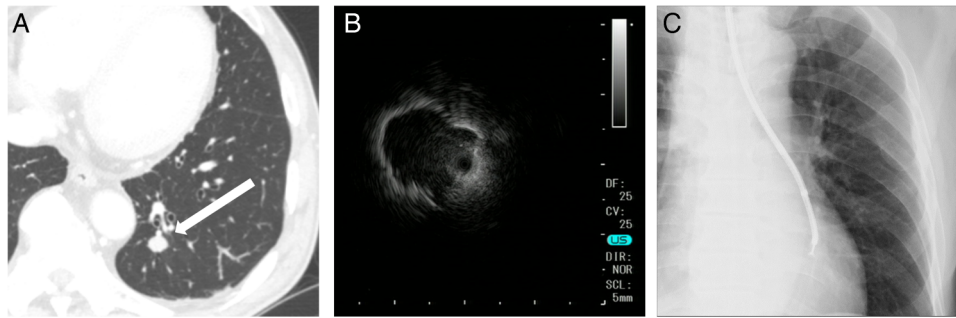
Successful tissue collection in patients with relapse of EGFR-positive adenocarcinoma after EGFR-TKI treatment. (A) Chest CT demonstrates a nodular lesion 12 mm in diameter in S10 of the left lung. (B) EBUS image shows a hypoechoic nodule with an irregular margin. (C) Transbronchial biopsy of the lesion detected by EBUS. EBUS, endobronchial ultrasound; EGFR, epidermal growth factor receptor.
